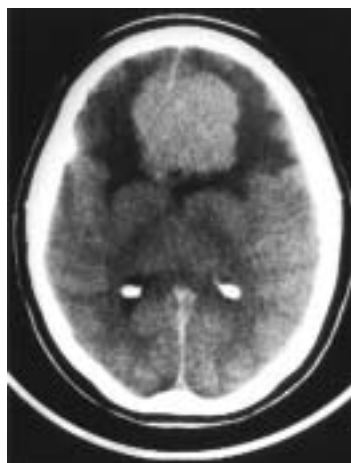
Post-contrast CT head scan showing a large enhancing falcine meningioma with considerable surrounding oedema in the frontal lobes.
